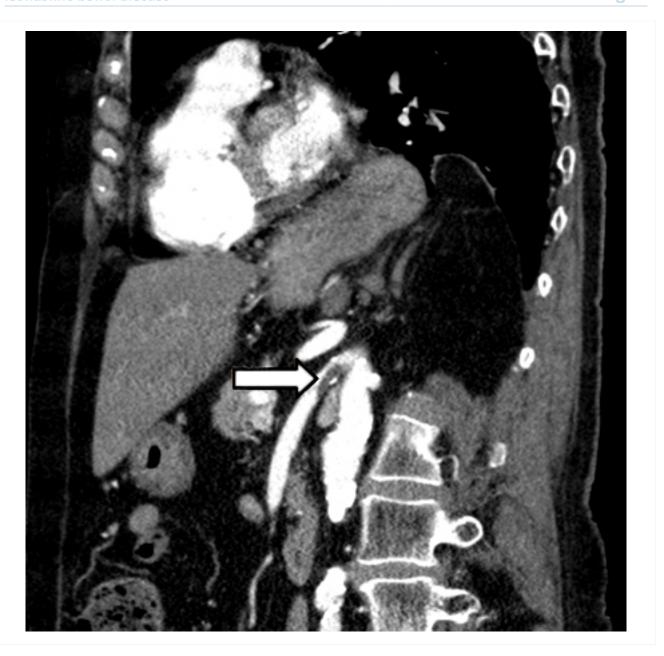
CT angiogram: Acute superior mesenteric artery thrombus
